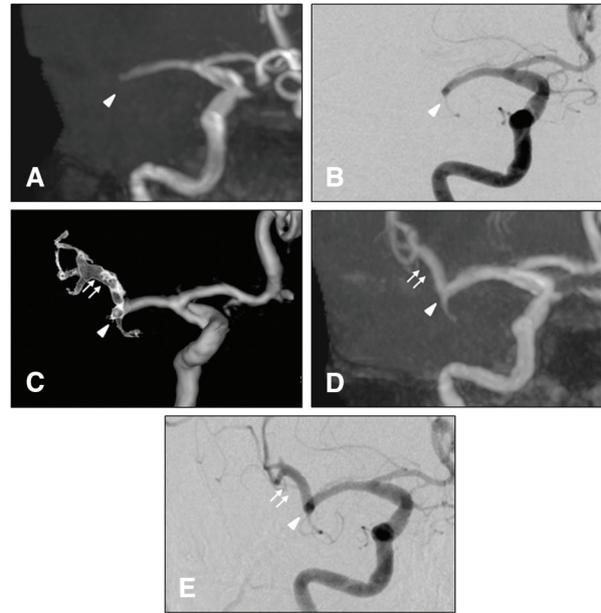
Detection of blood vessels beyond the occluded sites in the right MCA M1 distal segment occlusion case. This figure depicts images obtained in Case 2, with the occlusion point defined as the right MCA M1 distal segment. Original 3D TOF-MRA images obtained at admission do not delineate the course of the MCA distal to the occlusion site (A: white arrowhead). Angiography performed prior to MT (B) demonstrates a similar appearance as compared with 3D TOF-MRA at admission (A). Fusion images obtained from 3D T2-weighted SPACE and 3D TOF-MRA reveal the course of the MCA distal to the occlusion (C: white double arrows). This case was a monofurcation branching type, and M1–M2 exhibited a steep branching angle. The image delineation was rated “excellent.” MRA images (D) and angiography (E) acquired after MT match the fusion MR images (C) in terms of visualizing the MCA distal to the occlusion. Double arrows and arrowheads indicate the same point in the vessels. MCA: middle cerebral artery; MT: mechanical thrombectomy; SPACE: sampling perfection with application-optimized contrasts using different flip angle evolutions; TOF: time-of-flight
